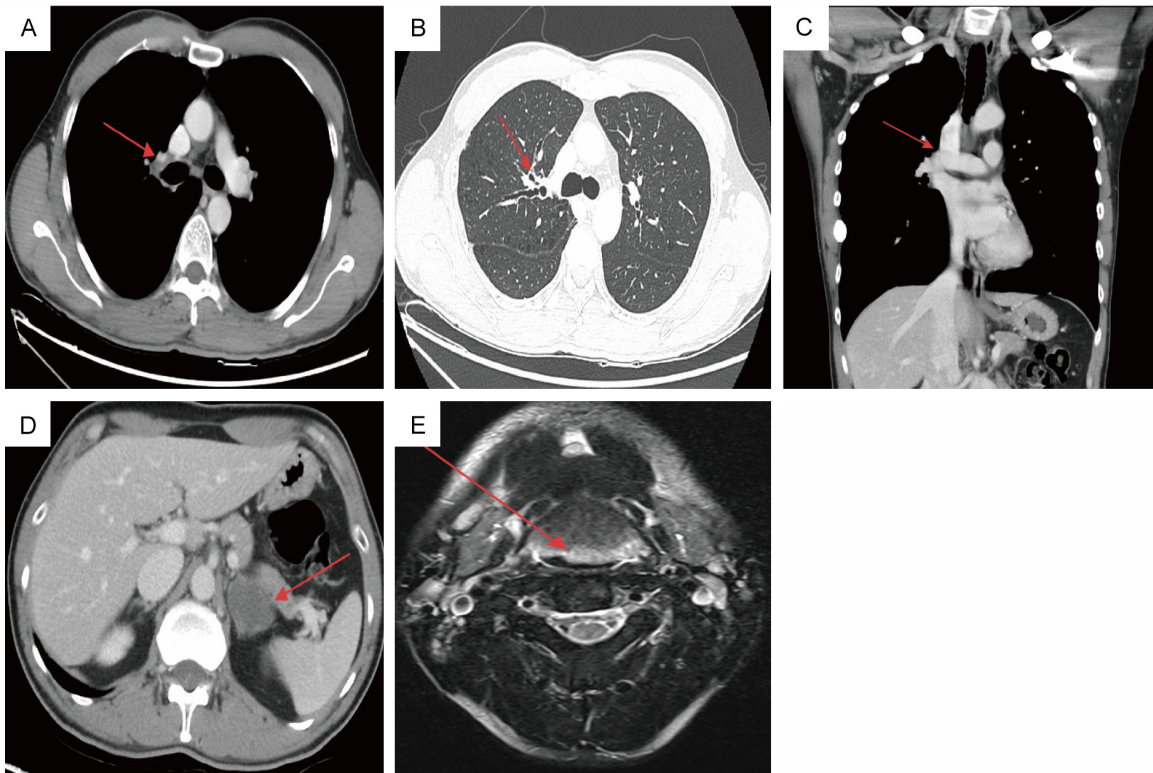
Response evaluation during the clinical course. A-C. After 3 cycles of treatment, follow-up CT demonstrated a significant reduction in the tumor, which measured approximately 1.3 cm × 1.0 cm × 0.6 cm (arrow). D. Follow-up abdominal CT after 3 treatment cycles revealed a markedly reduced mass, measuring 3.0 cm × 3.8 cm × 3.3 cm (arrow). E. The post-treatment MRI after 3 cycles revealed a modest decrease in the size of both the tongue base mass (approximately 3.5 × 1.5 × 1.5 cm; arrow) and the multiple bilateral cervical lymph nodes, the largest of which demonstrated a short-axis diameter of 0.7 cm.
